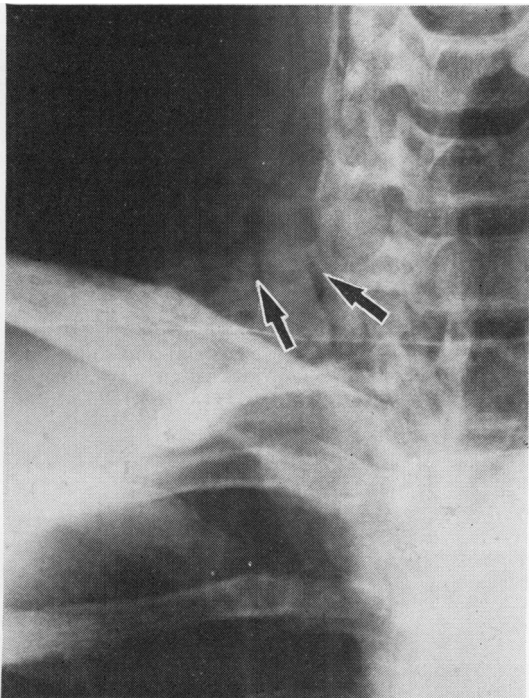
Posteroanterior radiograph showing subcutaneous emphysema above the right clavicle which led to the diagnosis of pneumomediastinum.
